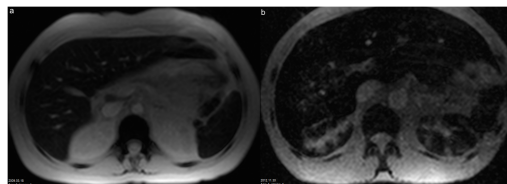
Iron assessment by MRI-R2* in the left renal cortex of patients with hemolytic anemia and matched LIC (images at TE=4.6 ms). Left: Patient with β -thalassemia major (30 y): R2* = 35 s⁻¹, LDH = 100 U/L, LIC = 2665 ± 300 $\mu\text{g/g}_{\text{liver}}$; Right: Patient with sickle cell disease (34 y): R2* = 475 s⁻¹, LDH = 987 U/L, LIC = 2814 ± 174 $\mu\text{g/g}_{\text{liver}}$.
